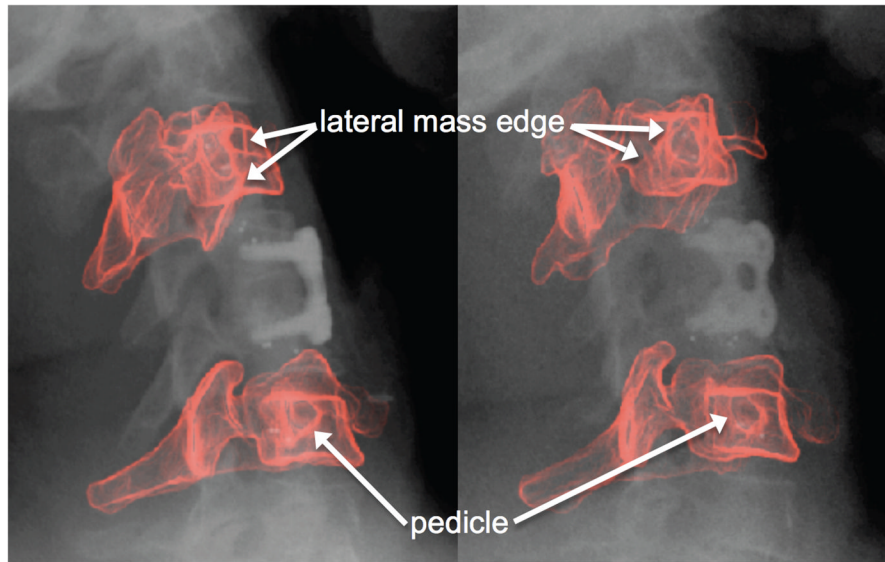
Magnified view of distortion-corrected X-rays with overlaid DRR in red. Note the “interior” anatomical features (e.g. lateral mass edge, pedicles) that can assist the model-based matching algorithm to properly position the bone. These interior features would not exist in a silhouette bone model.
